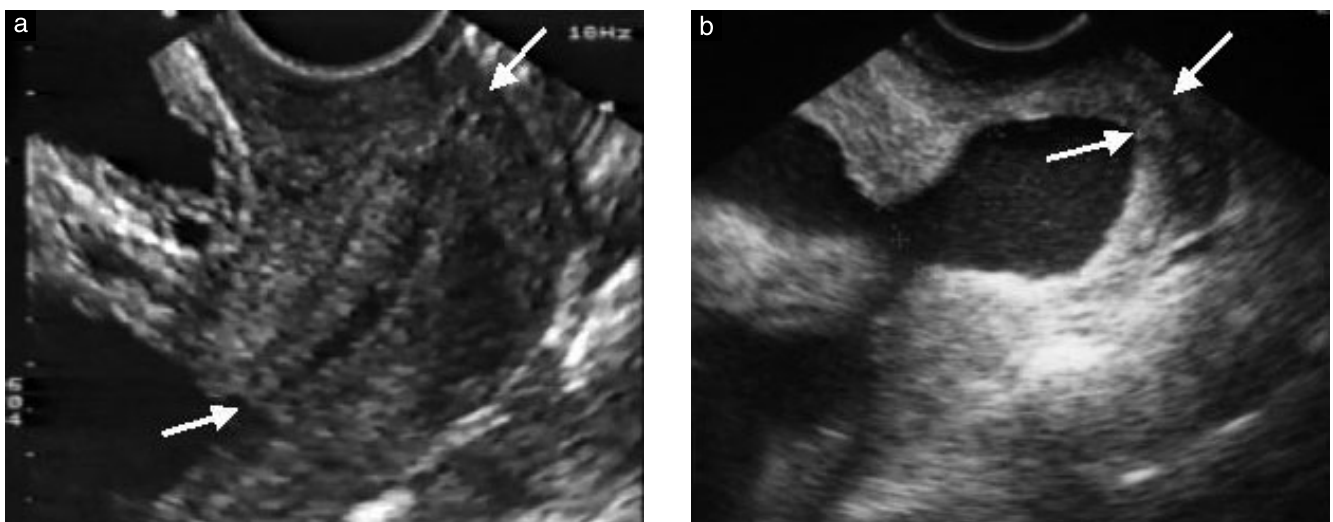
Transvaginal sonographic images of a long (a) and a short (b) cervix.
